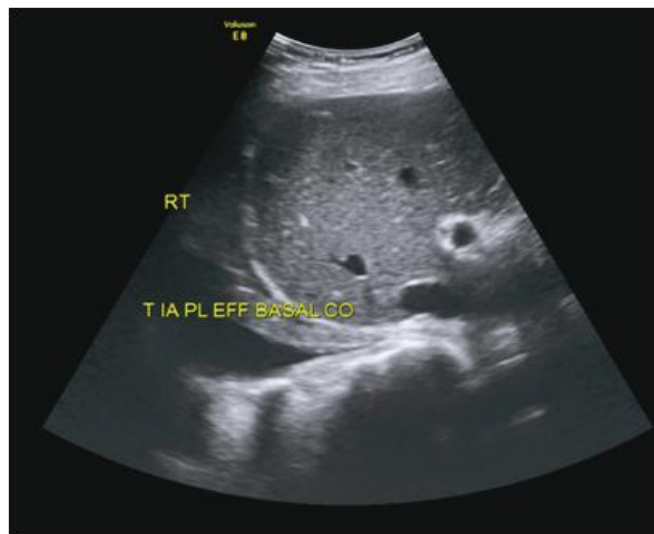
Screening ultrasound of chest showing effusion and basal consolidation of right side of chest
